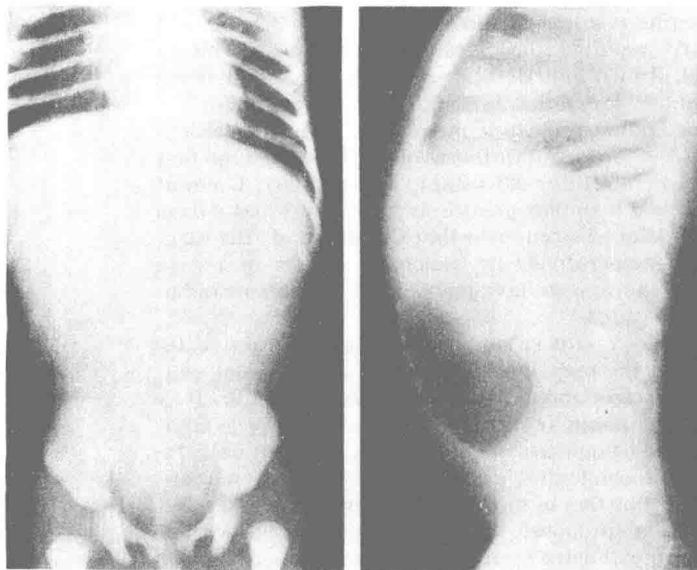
Partial prepyloric diaphragm. Upper gastrointestinal roentgenogram shows some narrowing at the prepyloric antrum with gastric retention at 4 hours. The patient, a boy of 11, had had intermittent vomiting since age 18 months. Excision of the incomplete mucosal diaphragm completely relieved symptoms.
